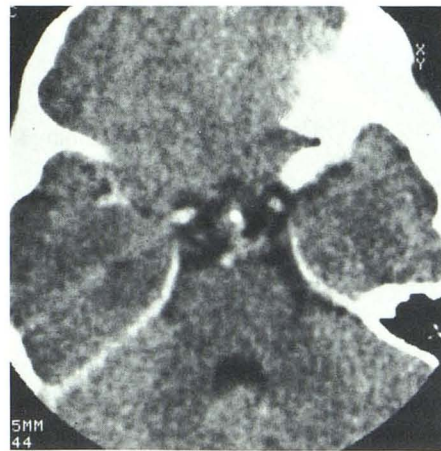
Axial (A) and sagittal (B) CT scans demonstrate 1-cm mass containing fat, calcium, and enhancing soft tissue above dorsum sellae in interpeduncular cistern, presumably representing a teratoma.
